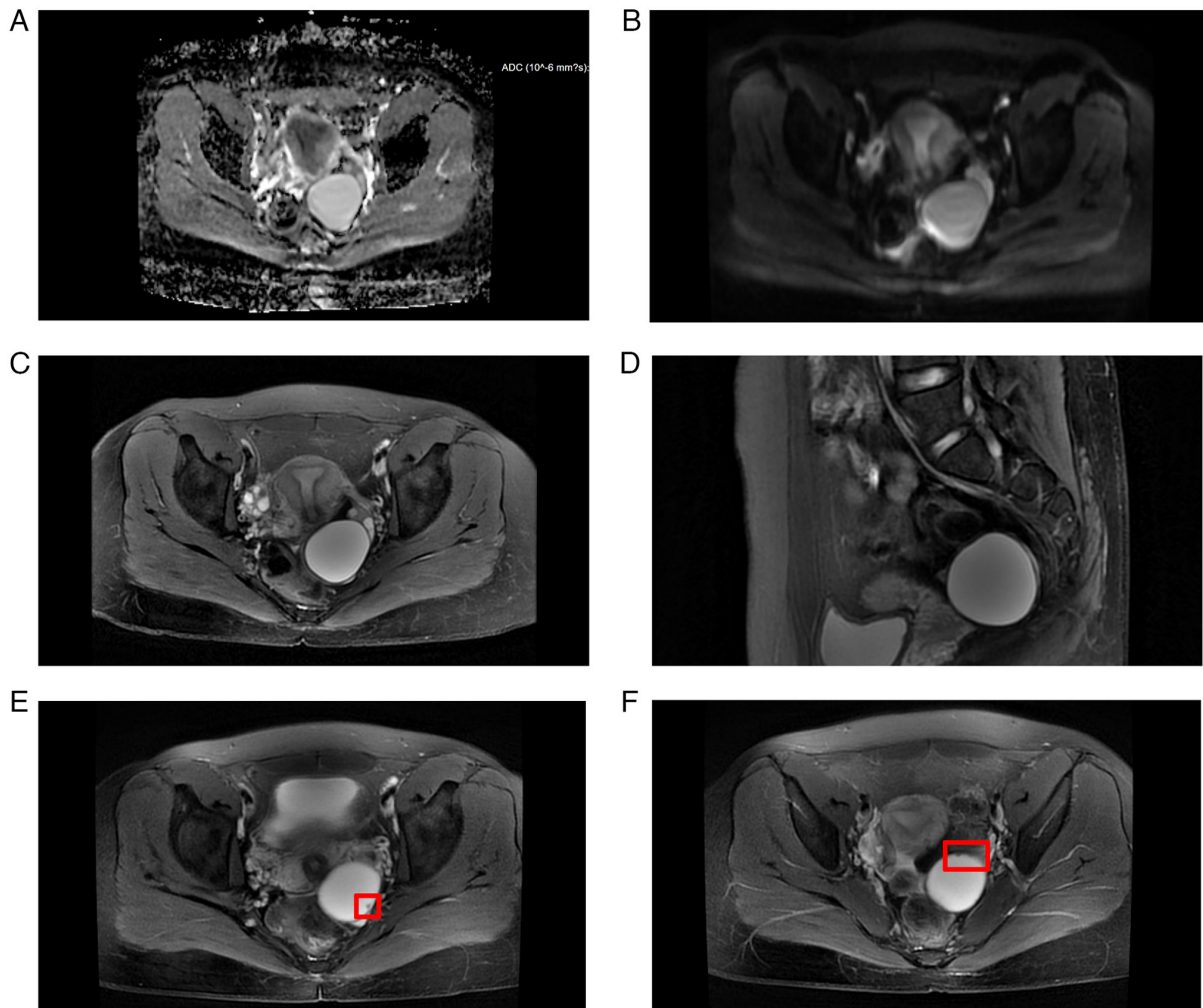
Magnetic resonance imaging appearance of serous papillary adenofibroma in various phases. (A) Transverse section in apparent diffusion coefficient phase. (B) Transverse section in diffusion-weighted imaging phase. (C) Transverse section in T2 phase. (D) Sagittal plane in T2 phase. (E) Transverse section in T2 phase with enhancement from one slice level (red rectangle shows spotted protrusion that is likely to be papillae). (F) Transverse section in T2 phase with enhancement from another slice level (red rectangle shows another spotted protrusion that is likely to be papillae).
